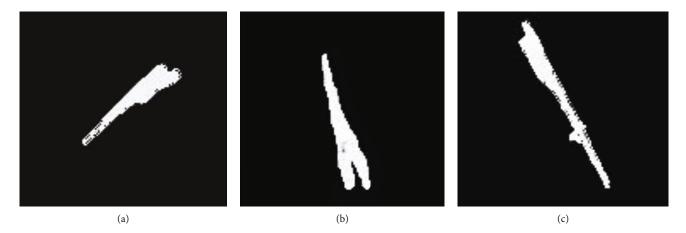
The blood vessel ultrasound images under intelligent 3D reconstruction. (a-c) The blood vessel images of three random patients, respectively.
